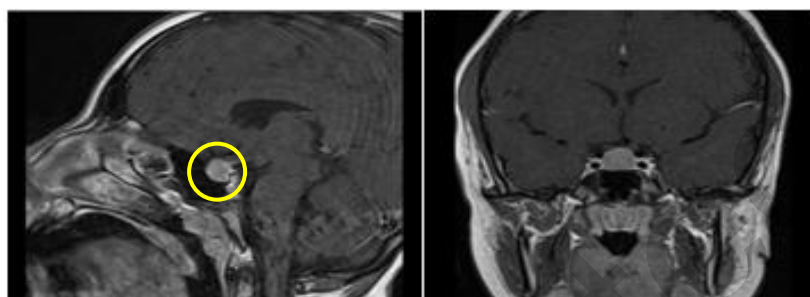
Coronal (right) and sagittal (left) T1-weighted MRI showing a 15 × 10 mm pituitary macroadenoma displacing the pituitary stalk without optic chiasm compression
